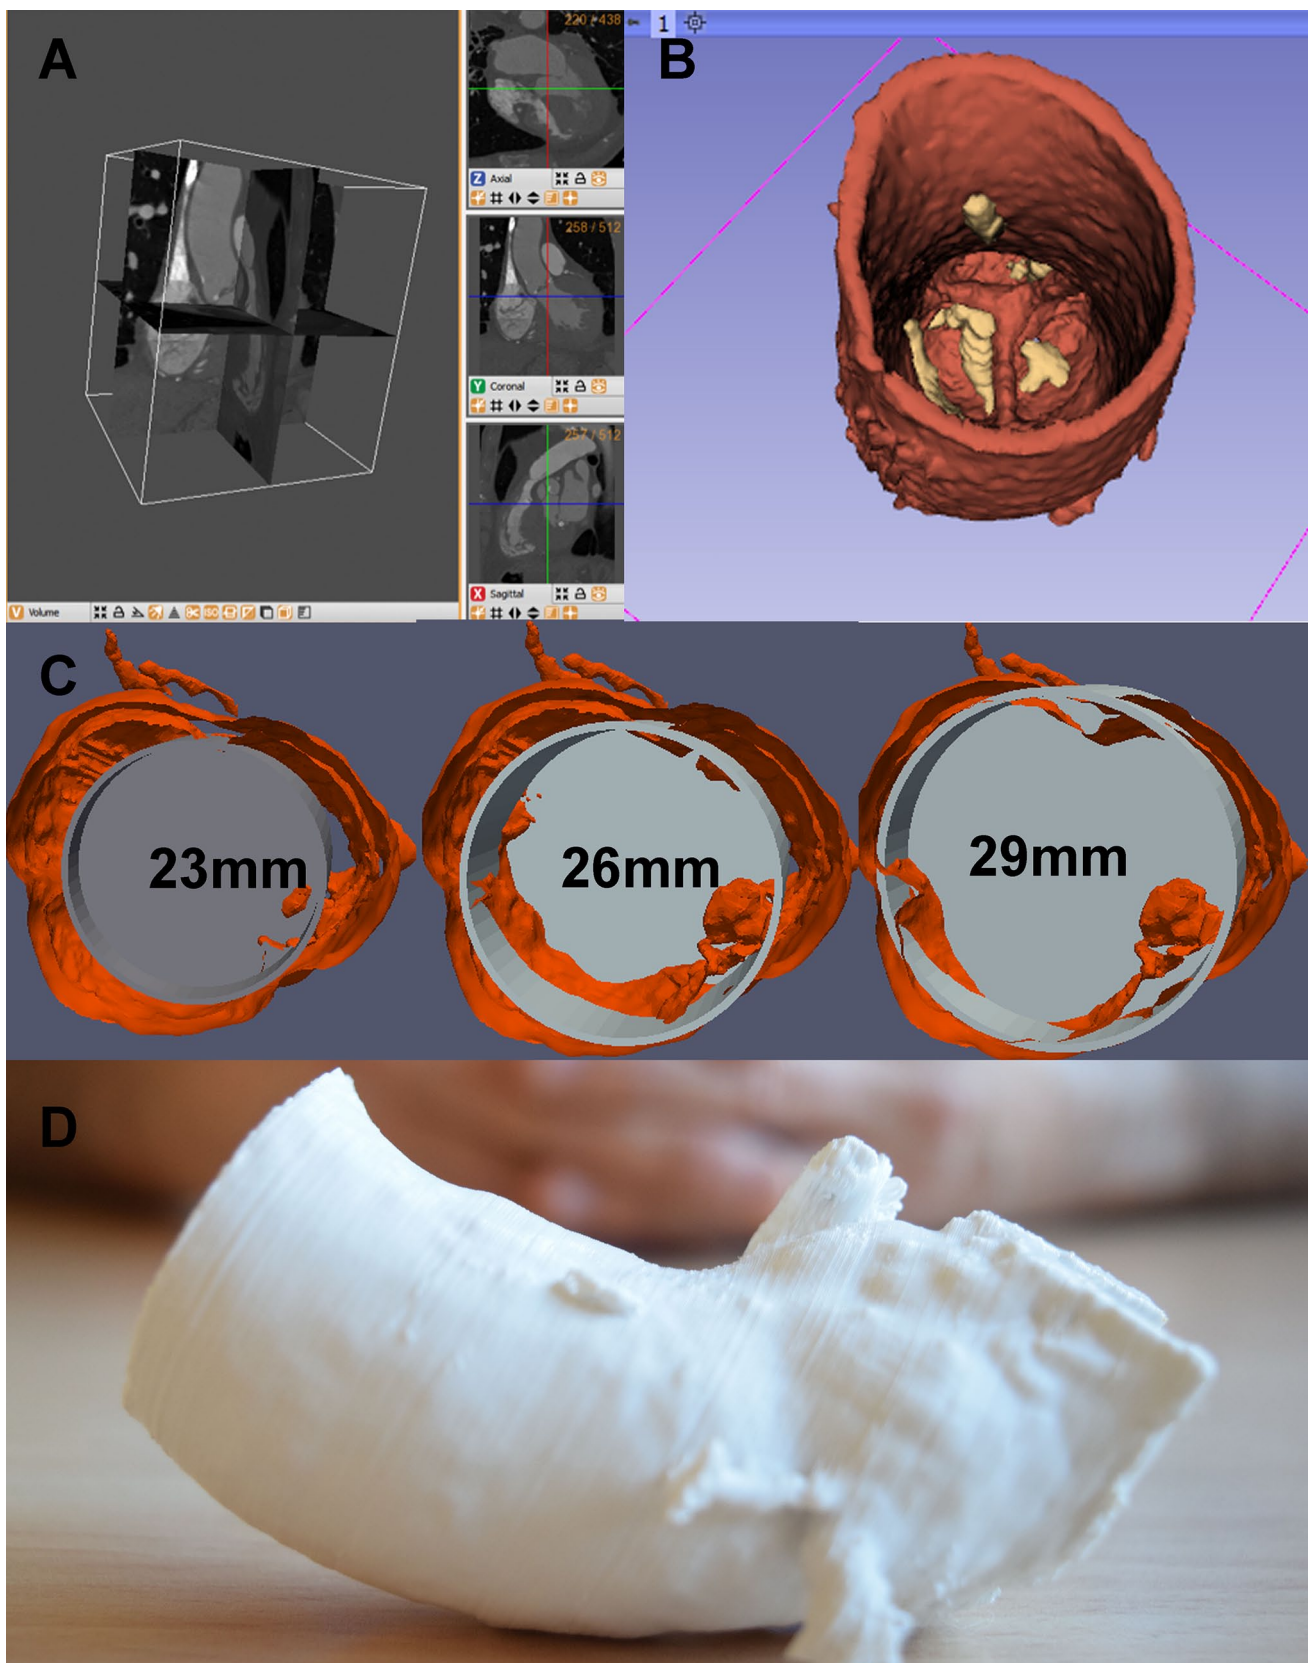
a Visualization of the CTA image obtained, loaded in DICOM format; b 3D surface model created from the aortic root segmentation. The aortic wall and valve are depicted in *red color* whereas
